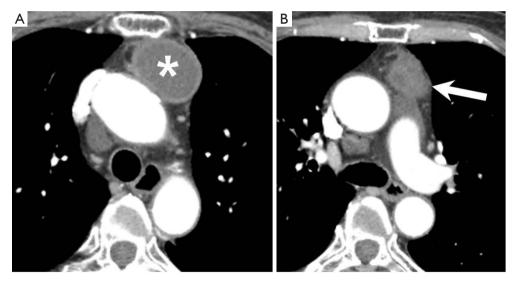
Follow-up CT scans reveal that the size of the cystic mass was decreased. The attenuation of the internal fluid is increased (asterisk in A), and the far inferior portion of the mass has changed to a solid component (arrow in B). CT, computed tomography.
